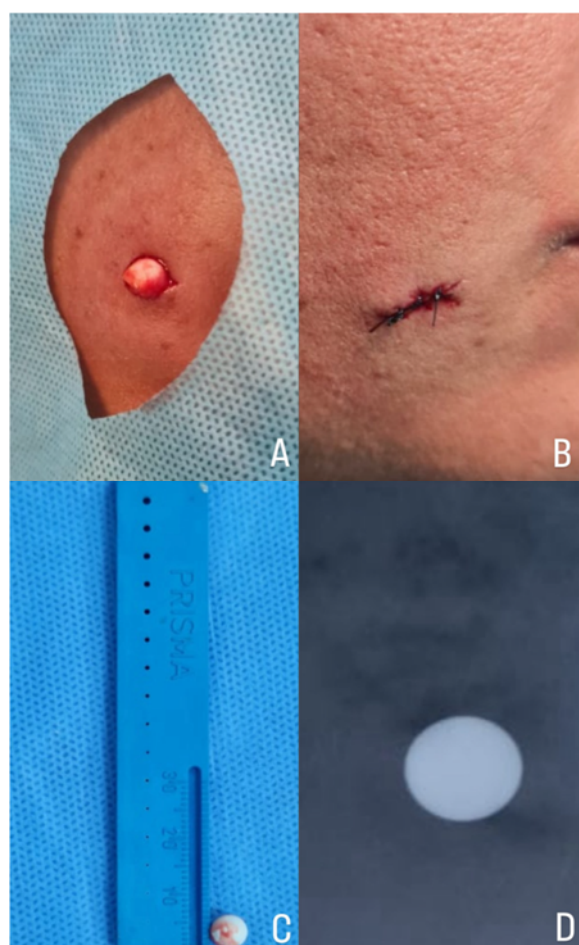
A. Complete exposure of the retained lead pellet; B. Wound closure with simple interrupted sutures using 5-0 nylon monofilament; C. Measurement of the extracted lead pellet; and D. Postoperative radiograph confirming the integrity of the lead pellet immediately after removal.
